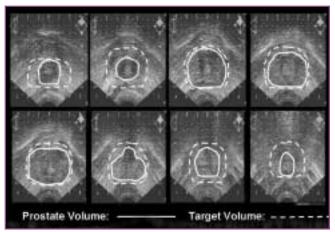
A Transrectal Ultrasound Prostate Volume Study. The prostate "map" is used to determine the number, activity, and precise coordinates of each seed's placement.
